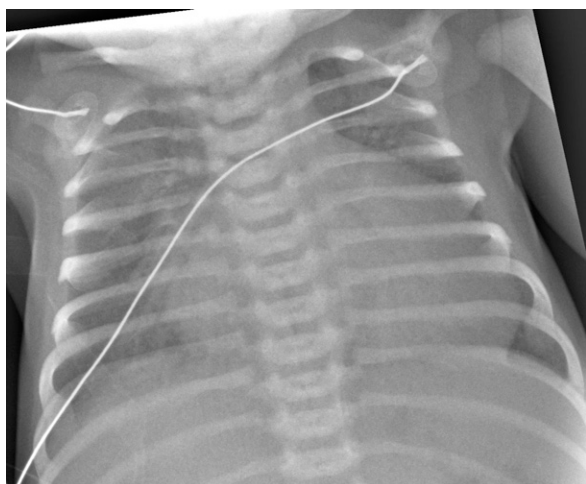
Chest radiograph demonstrating marked cardiomegaly with diffusely increased pulmonary vascularity.
